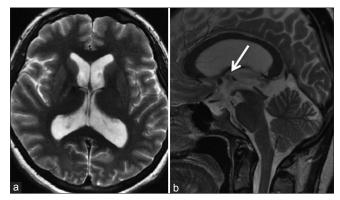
(a) A postoperative MRI displayed marked reductions in the size of the lateral and third ventricles. (b) The size of the quadrigeminal cistern arachnoid cyst was also reduced, and normalization of the cerebellar tonsillar descent was observed.The flow void artifact through the stoma with ETV was detected (arrow).
